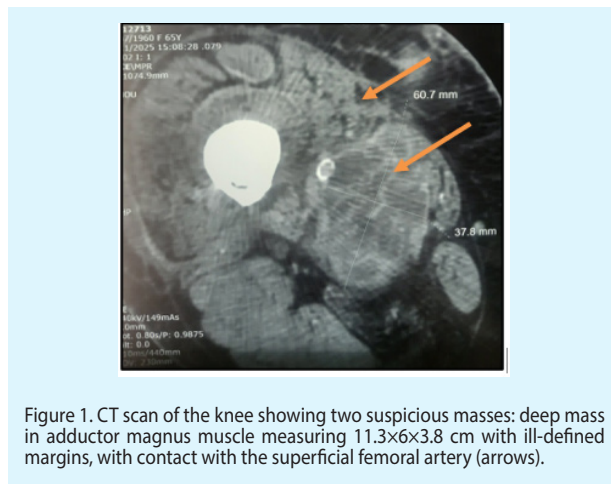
CT scan of the knee showing two suspicious masses: deep mass in adductor magnus muscle measuring 11.3×6×3.8 cm with ill-defined margins, with contact with the superficial femoral artery (arrows).
